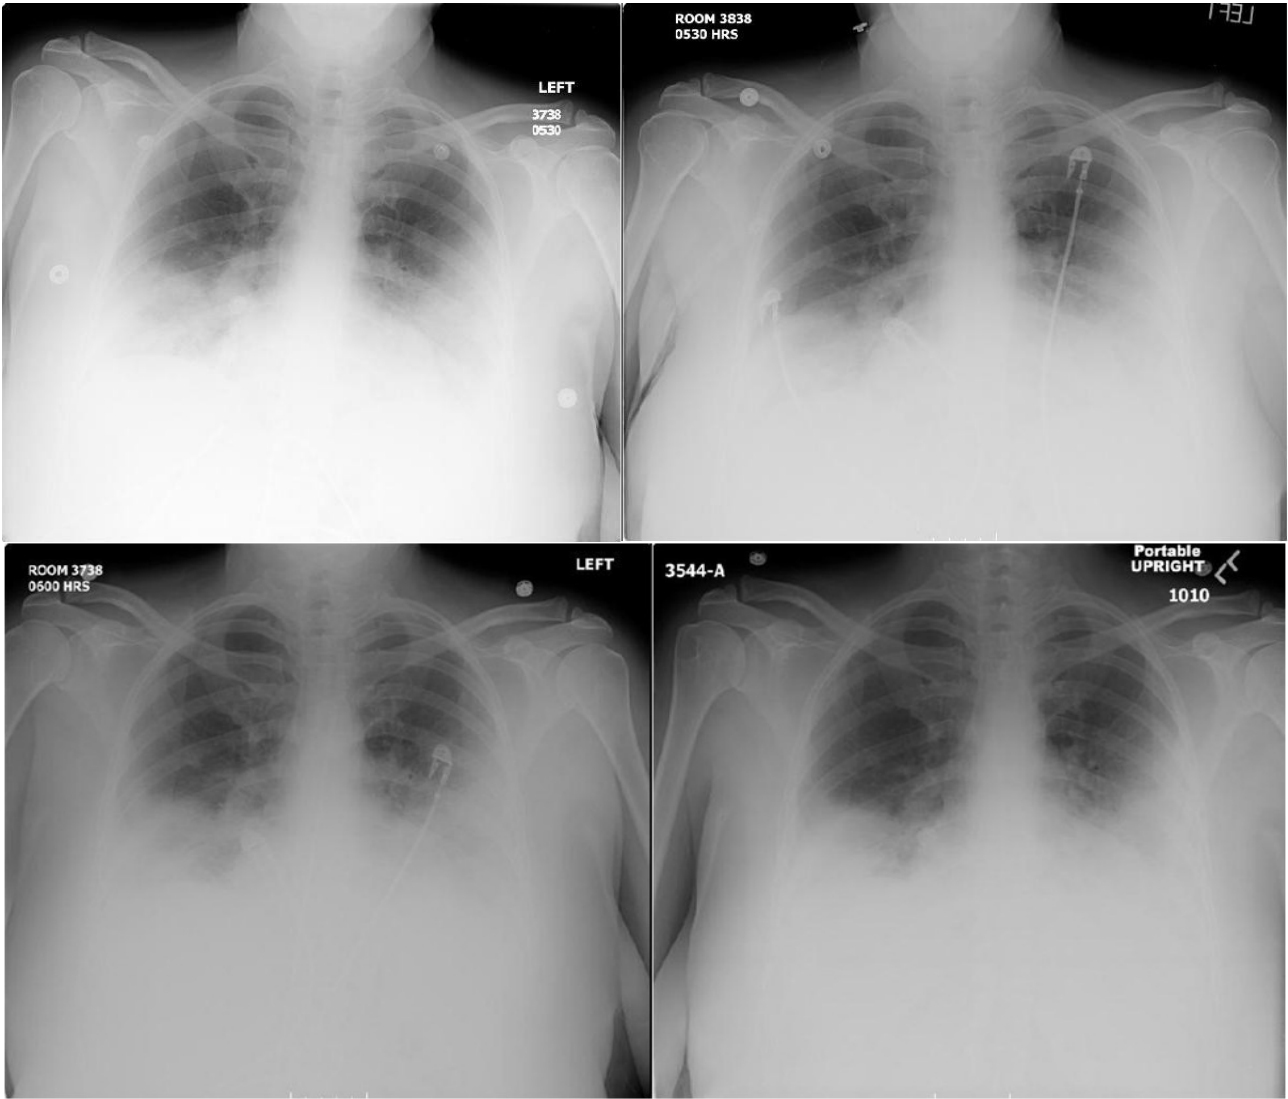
Four consecutive chest radiographs without any radiological worsening or improvement of infiltrates
